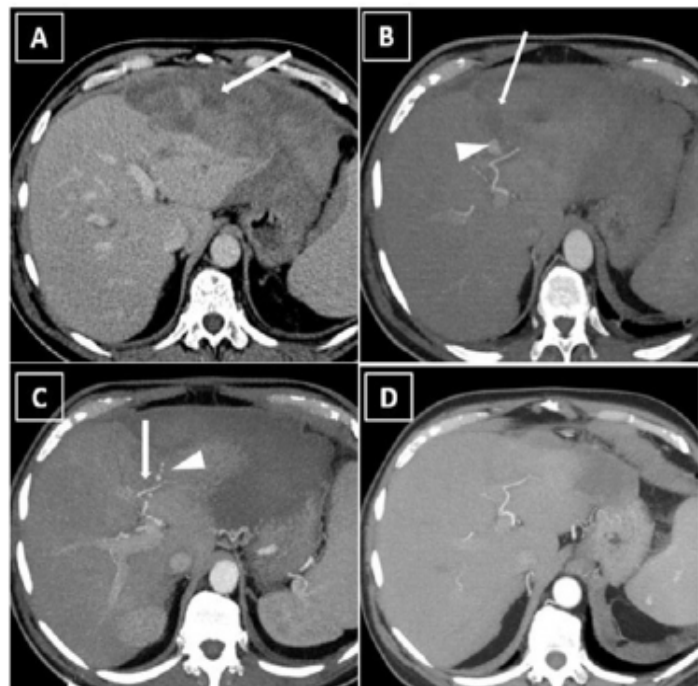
Contrast-enhanced CT scan during acute hemorrhagic event and follow-up(A-D). (A) Axial CT at portal venous phase showing bulby sub-capsular hematoma (arrow). (B) Axial CT at arterial phase, showing a well-defined pseudoaneurysm (arrow) of the left hepatic artery (arrowhead). (C) Axial CT at arterial phase, 10 days after hemorrhagic event and medical treatment showing thrombosis of left hepatic pseudoaneurysm (arrow) and multiples small pseudoaneurysm (arrowhead). (D) Axial CT at Arterial phase, 3 months after treatment complete normalization of CT images.
